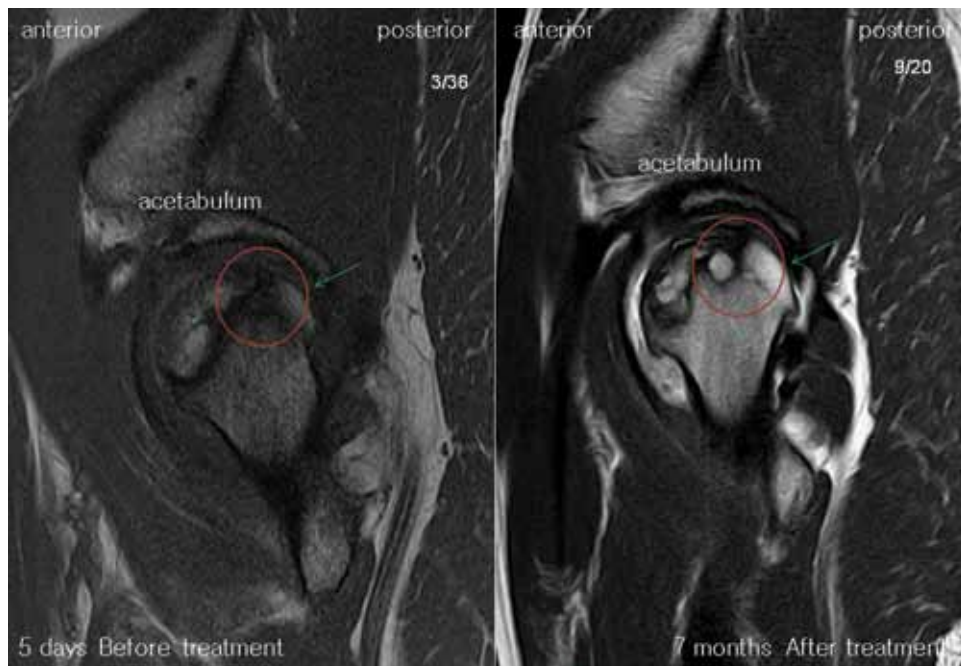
MRI results of Patient 2 (sagittal views). T1 sagittal views showing apparent signal changes along the posterolateral injection site.
